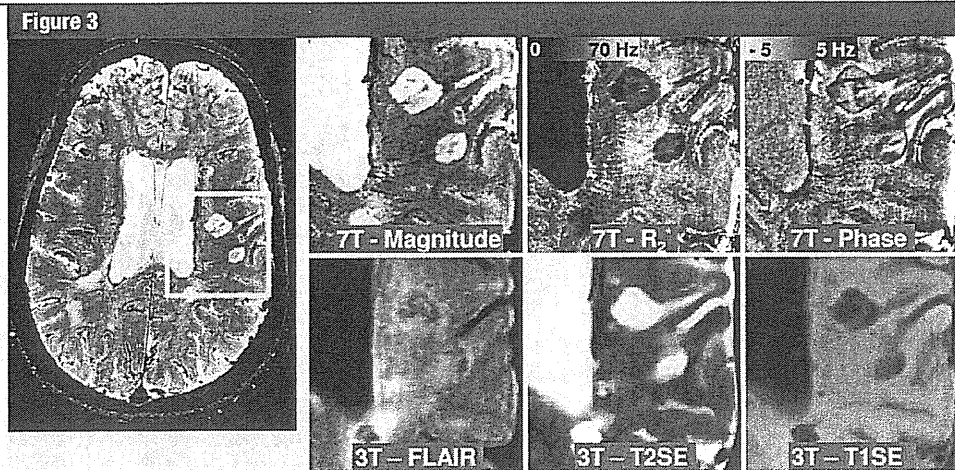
Transverse MR images in 40-year-old man with RR MS, an EDSS score of 2.5, and 7.5 years of disease show lesion with inhomogeneous intensity and contrast at its rim. Lesion contrast varies across various image types, including susceptibility-weighted magnitude, phase, and R2\* images obtained at 7.0 T and FLAIR, T2-weighted spin-echo (T2SE), and T1-weighted spin-echo (T1SE) images obtained at 3.0 T. Intensity scaling of each image was adjusted to accentuate the lesions.
